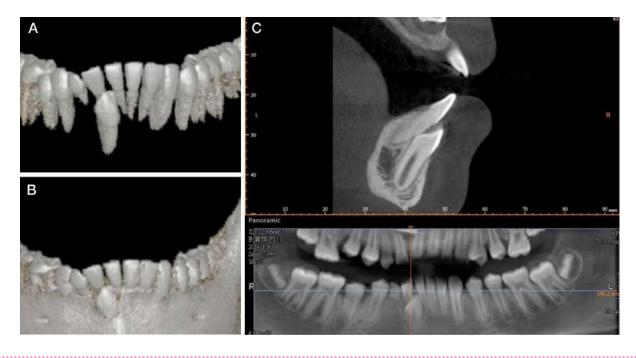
Pre-treatment CBCT
